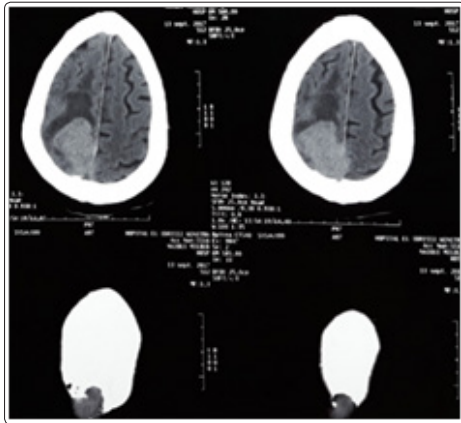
CT scan show the mass and lytic bone and attached of sinus longitudinal
